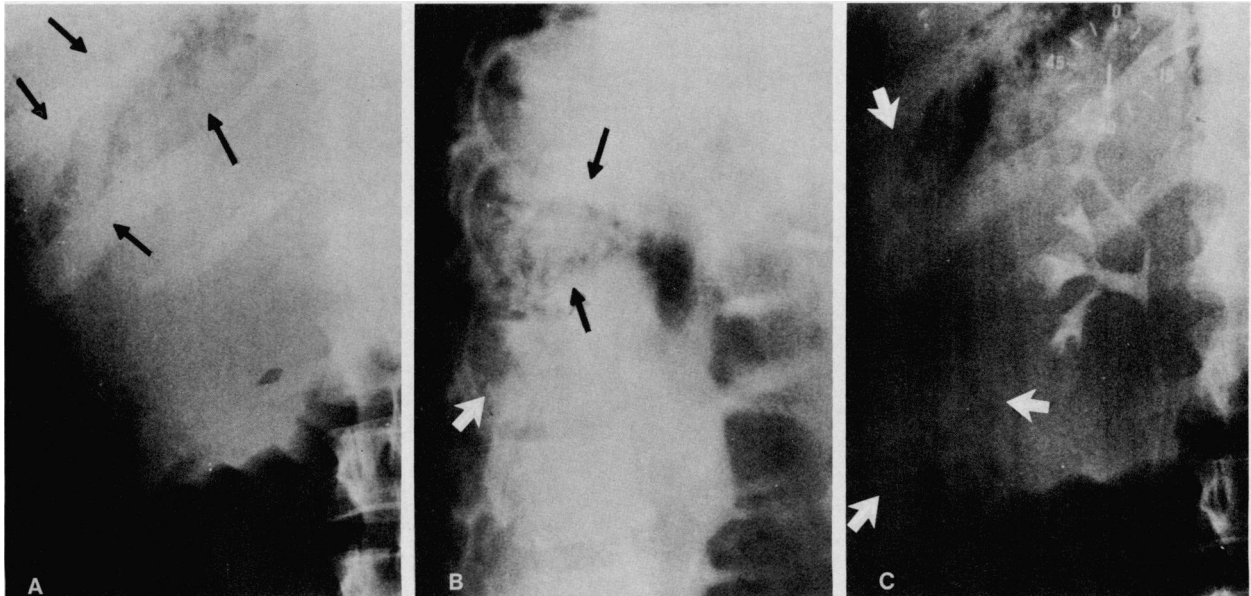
(Case 1). (A) Abdominal roentgenogram shows extraluminal mottled gas pattern extending from the lumbar area to the right upper quadrant (arrows). (B) Lateral view of abdominal roentgenogram demonstrates a posterior location of the abscess. (C) IVP demonstrates extraperitoneal gas outlining the right kidney and extending to the right lower quadrant (arrows), which reflects retroperitoneal abscess formation
